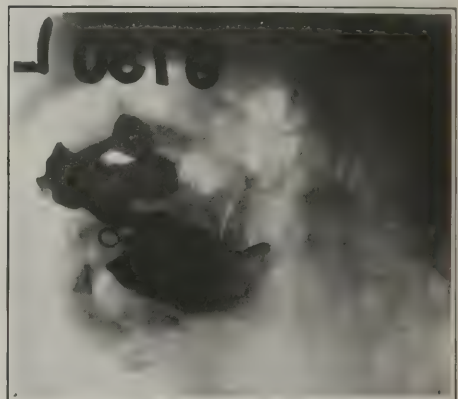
Radiograph showing osteoperiosteal graft, which was necessary to span the gap.
